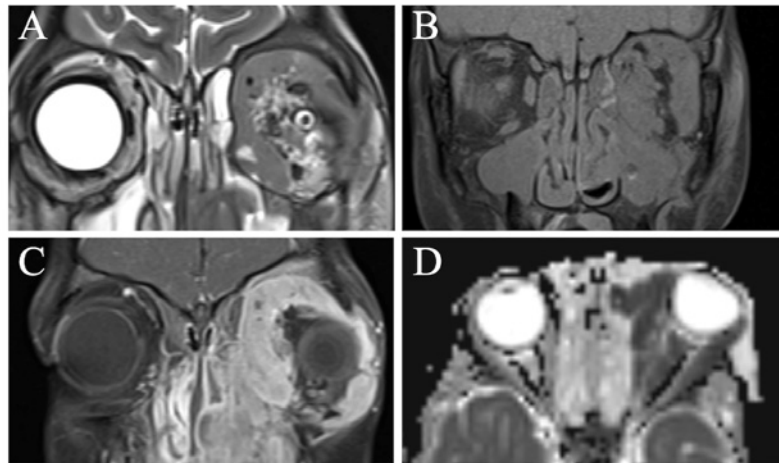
MRI demonstrates an extensive mass involving the left orbit, ethmoid and maxillary sinuses that is (A) hypointense on both T2 and (B) T1 weighted images with (C) avid post contrast enhancement (D) and marked diffusion restriction on ADC
